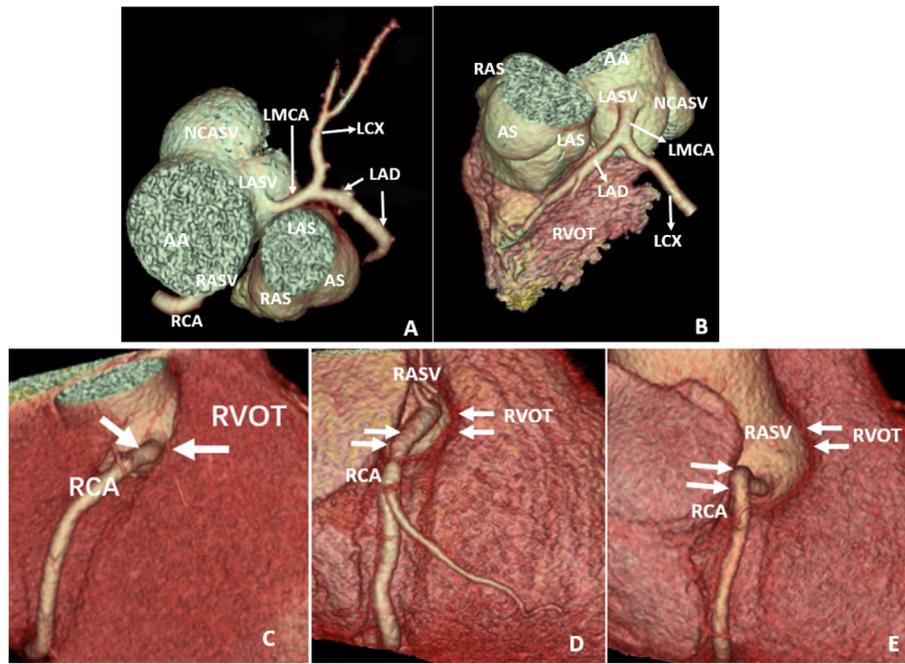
CT 3D reconstructions of pulmonary root. A, B) Superior and left anterior view showing the relationship between the LMCA and pulmonary valves and related structures. C–E) Right lateral view showing three relationships between the RCA and RVOT in ≤ 2 mm, 2–5 mm and > 5 mm, respectively. LMCA = left main coronary artery; LAD = left anterior descending artery; LCX = left circumflex coronary artery; RCA = right coronary artery; LPSV = left pulmonary sinus of Valsalva; APSV = anterior pulmonary sinus of Valsalva; NCASV = noncoronary aortic sinus of Valsalva; RPSV = right pulmonary sinus of Valsalva; LASV = left aortic sinus of Valsalva; RASV = right aortic sinus of Valsalva; RVOT = right ventricular outflow tract.
